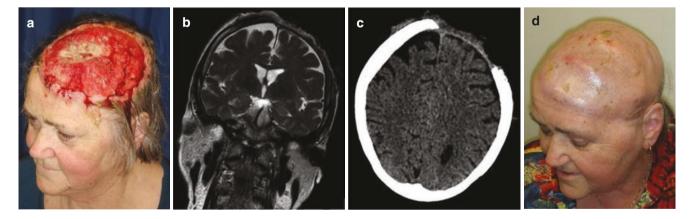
An extensive scalp SCC with destruction of the soft tissues and underlying skull and invasion of the dura (a) also demonstrated on MRI (b) and CT (c) scans, treated with surgery and adjuvant radiotherapy (d). (*Reprinted from* Mistry et al. [5]; *with permission*)
